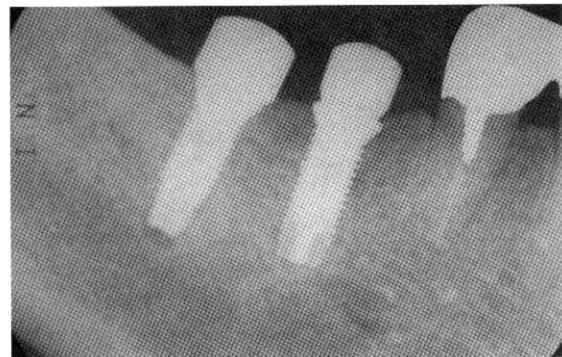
Periapical x-ray was taken immediately following implant placement. Note the step between implant shoulder and healing abutment in the right implant for first molar.
